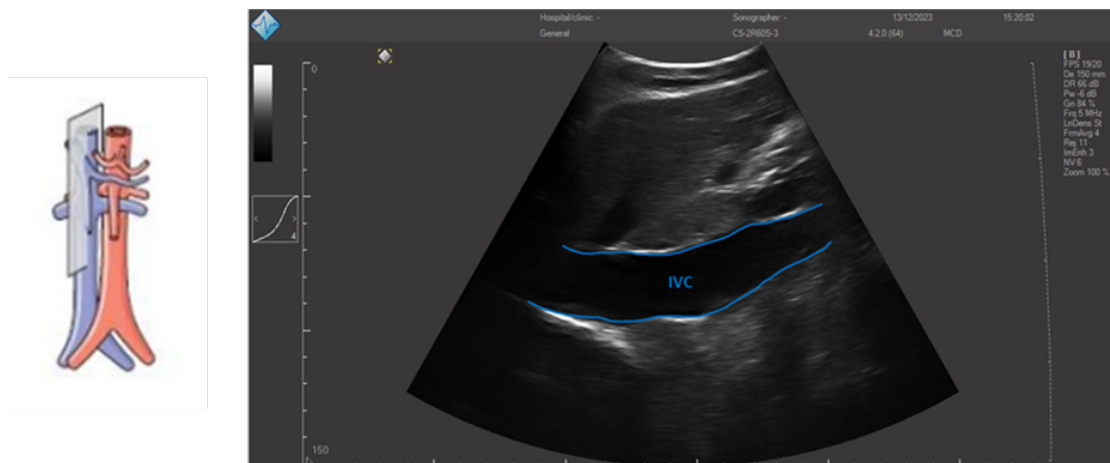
Imaging plane (left) and ultrasonographic image of the IVC scanned along the longitudinal view (right)*
